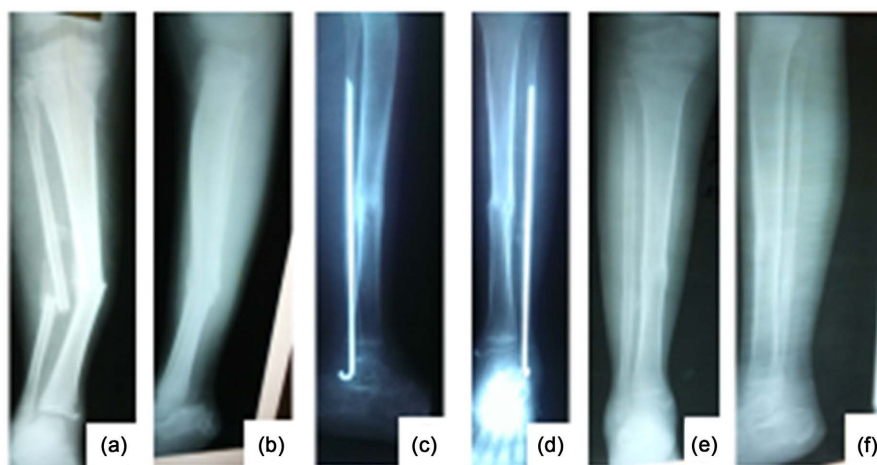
Open Gustilo II middle third fracture treated by pinning 3 weeks later (vicious callus in formation) due to lack of surety (13 years). Preoperative Rx of face (a) and profile (b). Postoperative Rx of profile (c) and face (d) at 12 weeks (jointed and uniform callus with disappearance of the fracture line). Postoperative X-ray of the face (e) and profile (f) at 6 months (no trace of fracture).
